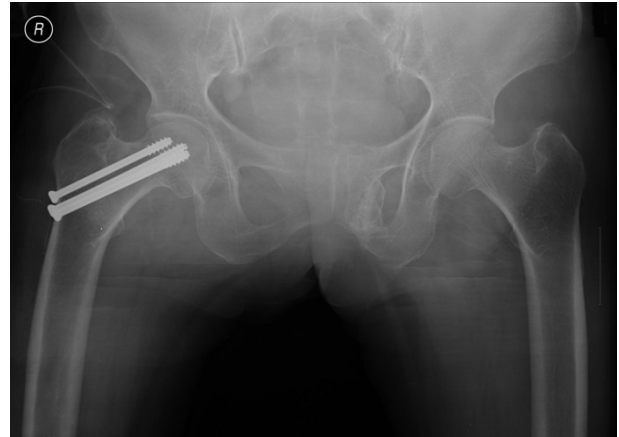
Postoperative radiograph shows a well fixed 3 cannulated cancellous screws inside the femoral neck.
